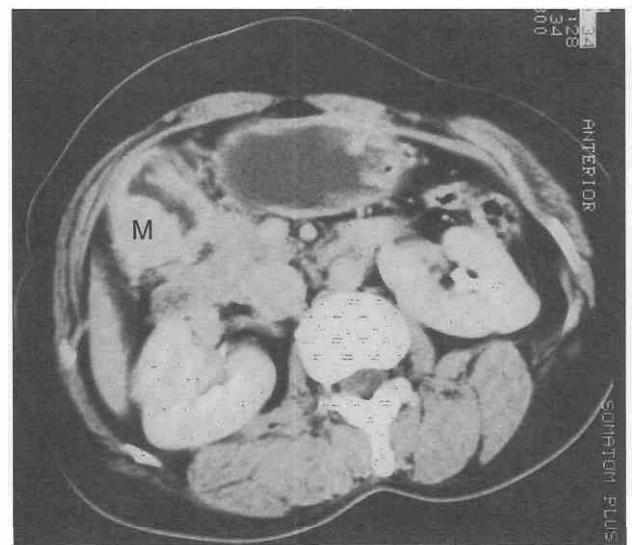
Ectopic pancreas in the stomach. CT scan shows a submucosal mass (M) in the prepyloric antrum of the stomach.
